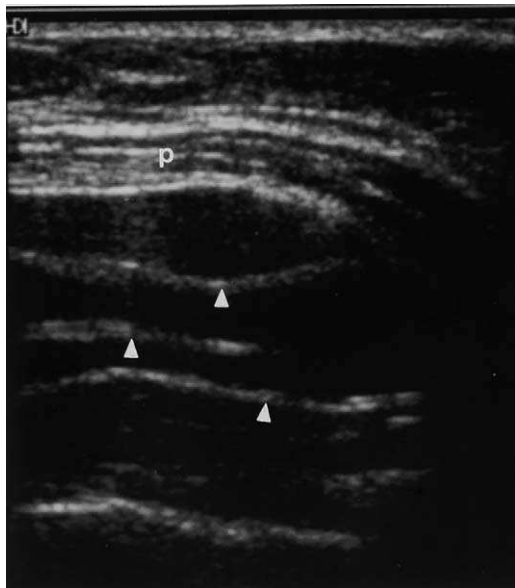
Implant. Ultrasound shows a subpectoral implant (P, pectoralis muscle) with “stepladder sign” (arrowheads). Surgery revealed an intracapsular rupture.
